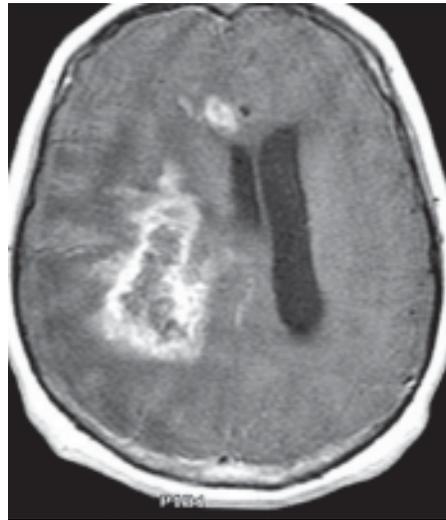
MRI (postcontrast T1) demonstrated an enhancing mass in the right hemisphere. Biopsy revealed only necrosis (diffuse necrotizing leucoencephalopathy).
